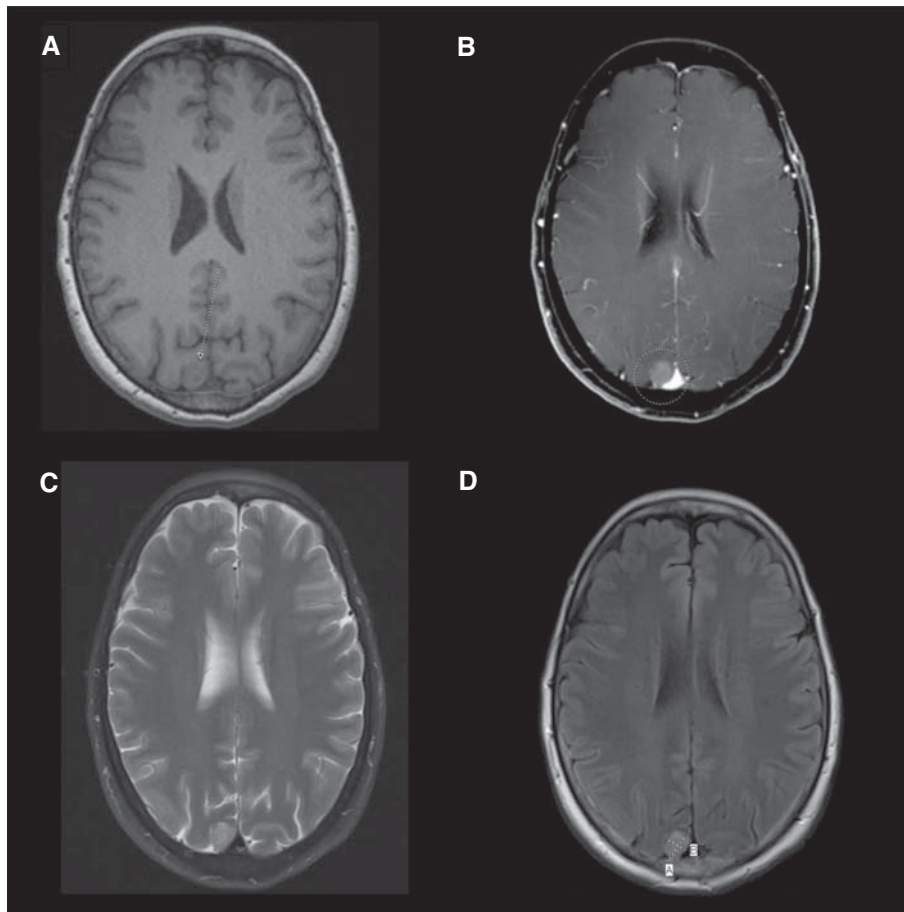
MRI T1 axial view (A) showing rounded hypointense lesion. MRI T1-post (B) showing lesion with minimal abnormal homogenous enhancement. MRI T2 axial view (C) and FLAIR axial view (D) showing rounded hyperintense signal abnormality in the parasagittal right occipital lobe measuring 1.3 cm × 1.0 cm × 1.3 cm.
